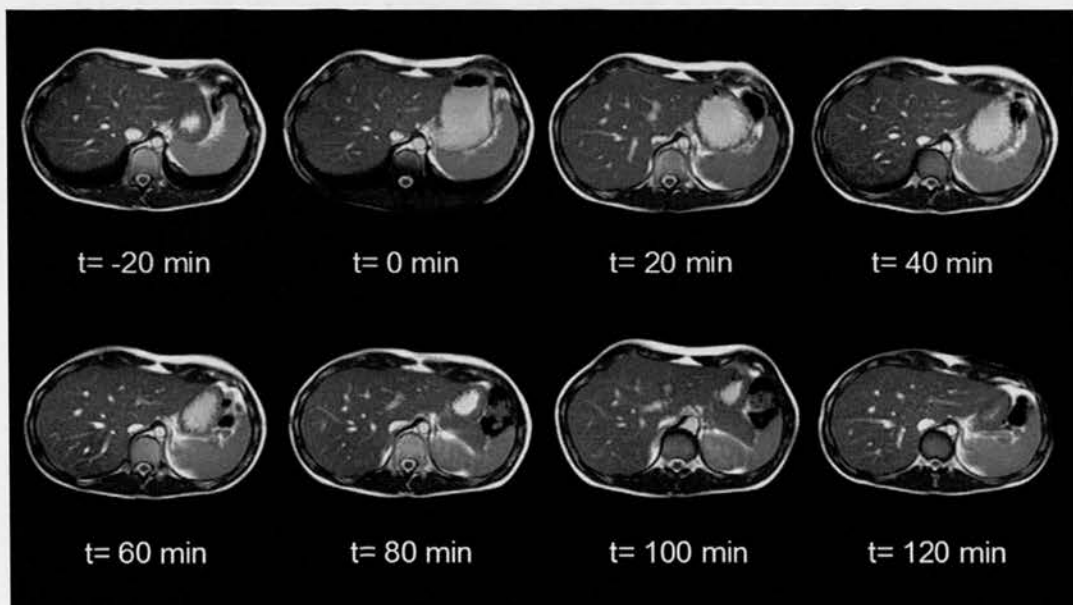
Sequential axial MRI scans in one subject before and after ingestion of the drink.
